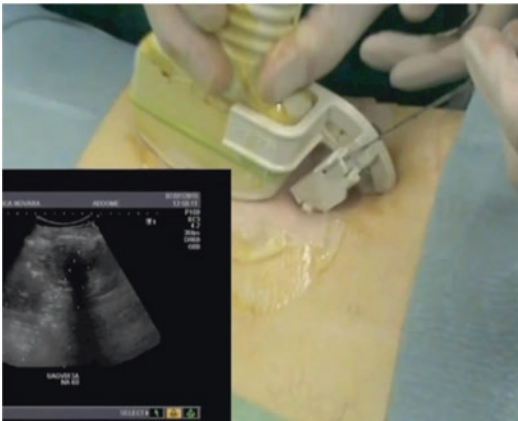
Skin puncture and advancement of the guiding cannula to reach the tumor capsule under ultrasound guidance
